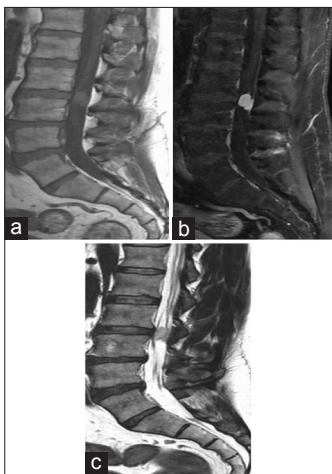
Preoperative sagittal MRI (a) T1 and (b) T1+ Gadolinium showing homogeneous enhancement (c) T2 showing an isointense to mildly hyperintense lesion
